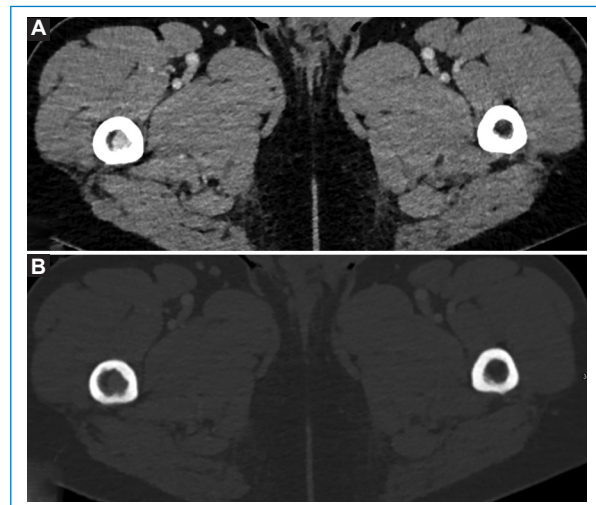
Axial CT of femoral shafts with soft tissue window (A) and bone (B) showing increased density of the right femoral medullary cavity, compared to the contralateral one with adipose density.
